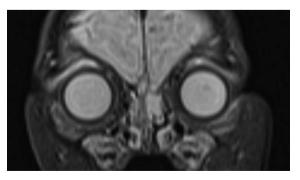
Frontal view in a T2-weighted MRI scan showing no connection between the mass and the brain tissue
